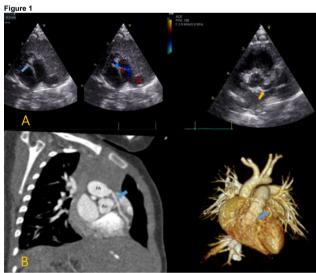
(A) echocardiogram: right coronary artery from the pulmonary artery (blue arrow); increased left main coronary artery diameter (yellow arrow); (B) CT-angiography: right coronary artery from the pulmonary artery (blue arrow); PA: pulmonary artery; Ao: aorta
